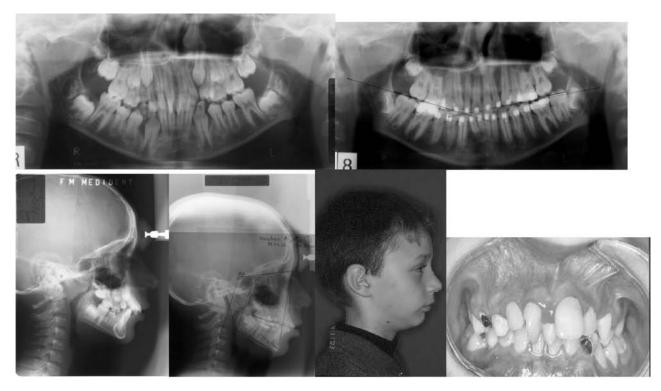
Patient V. A., male, orthopantomograms and lateral skull radiographs at the ages of 9 years and 11 months, 13 years and 8 months, initial profile and intraoral aspects
